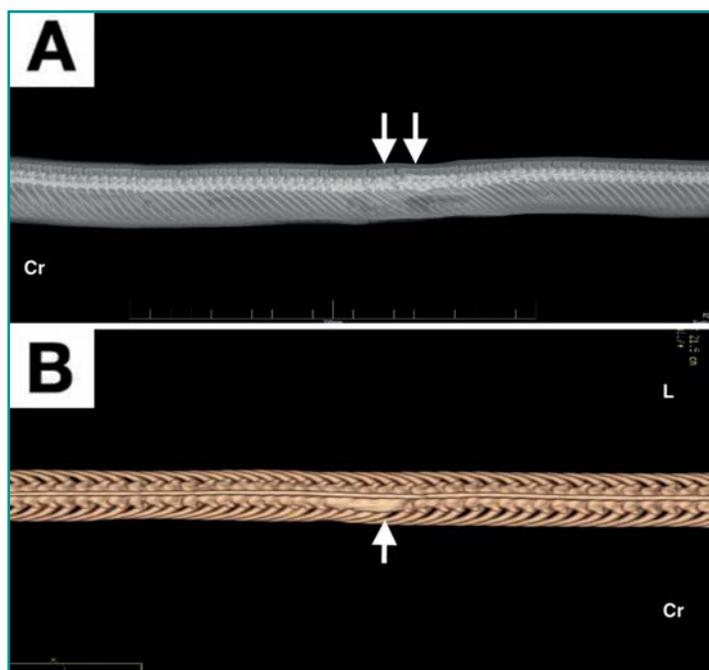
A, B) Comparison between X-rays (LL view) and CT-scan, that reveal a mixed osteolytic-proliferative bone lesion involving six vertebral bodies in the first third of the spinal tract.
